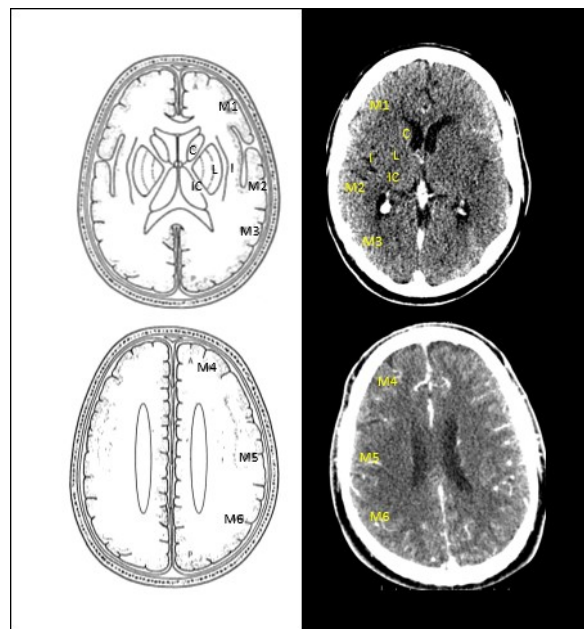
Alberta Stroke Program Early CT Score (ASPECTS) Template. A comparison of the ASPECTS system (left) in an acute ischemic stroke patient (right). ASPECTS is scored out of 10 based on 6 MCA cortical regions (M1-M6), the caudate (C), lentiform (L), internal capsule (IC), and insula (I).¹⁰
